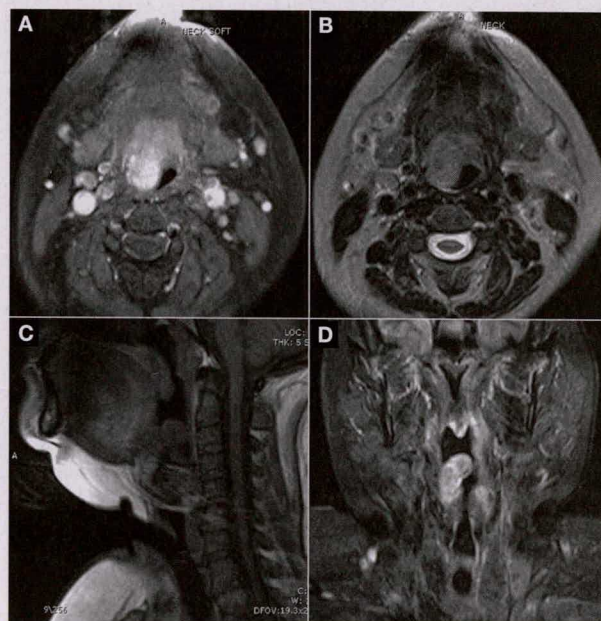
Axial T1-weighted postcontrast (A) and axial T2-weighted (B) MRIs of the oropharyngeal myofibroma show that it is nearly obliterating the airway. Sagittal T1-weighted precontrast (C) and coronal short T1-weighted inversion recovery (D) images are also shown.
